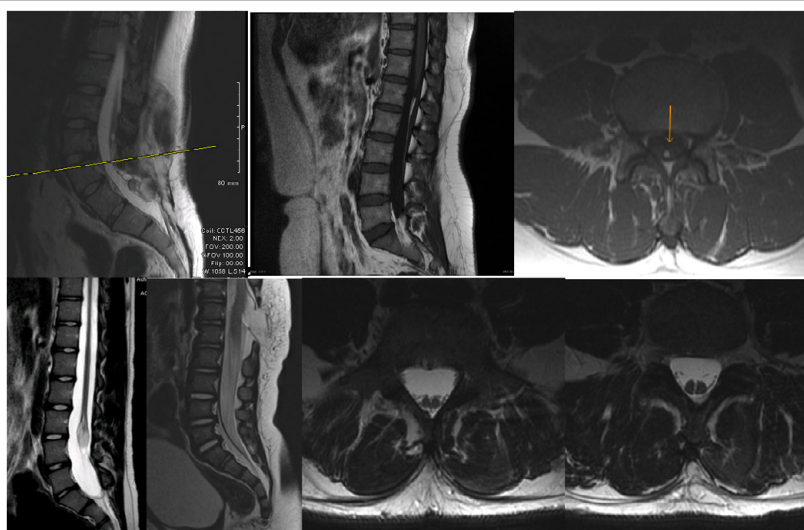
Classification of tethered cord etiologies. From top left, counterclockwise: T2-weighted sagittal lumbar MRI demonstrating retethering following myelomeningocele repair with conus at L4. T1-weighted sagittal (top middle) and T1-weighted axial (top right) MRI with a fatty filum greater than 2mm thick (orange arrow). T2-weighted axial lumbar MRI showing diastematomyelia type I (left) and type II (right) given the presence and absence of separate dural sleeves, respectively. T2 weighted sagittal MRI demonstrating tethering secondary to terminal lipoma at L3/4 (left) and lipomyelomeningocele at T12/L1 (right).
